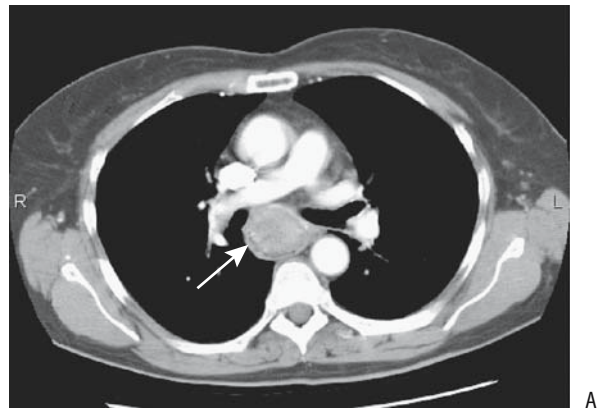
Squamous cell carcinoma in mid-esophagus. A: CT identifies a poorly enhancing tumor infiltrating the esophagus (arrow). (Courtesy of Arunas Gasparaitis, M.D., University of Chicago.) B: Ulcerated carcinoma in mid-esophagus (arrow) in another patient.
